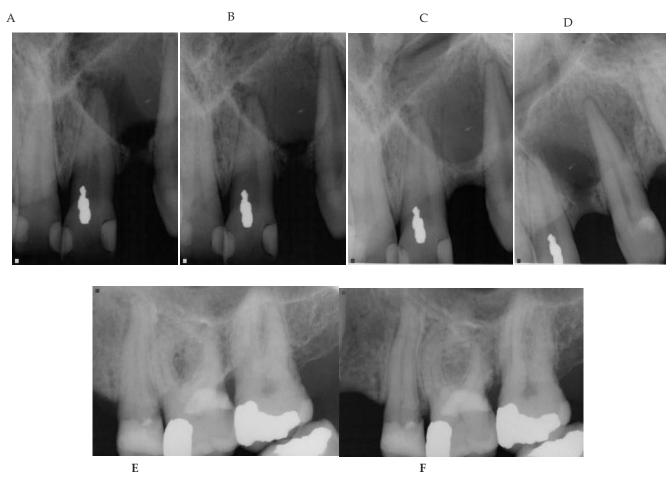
Pre-operative periapical radiographs (A-D) showing a large well-defined radiolucent lesion in the apical region of maxillary left central incisor and centeredaround maxillary canin. E and F showing pre-operative periapical radiograph ofmaxillary posterior teeth demonstrating a periapical radiolucency of approximately 2 X 4 mm around roots of second premolar.
